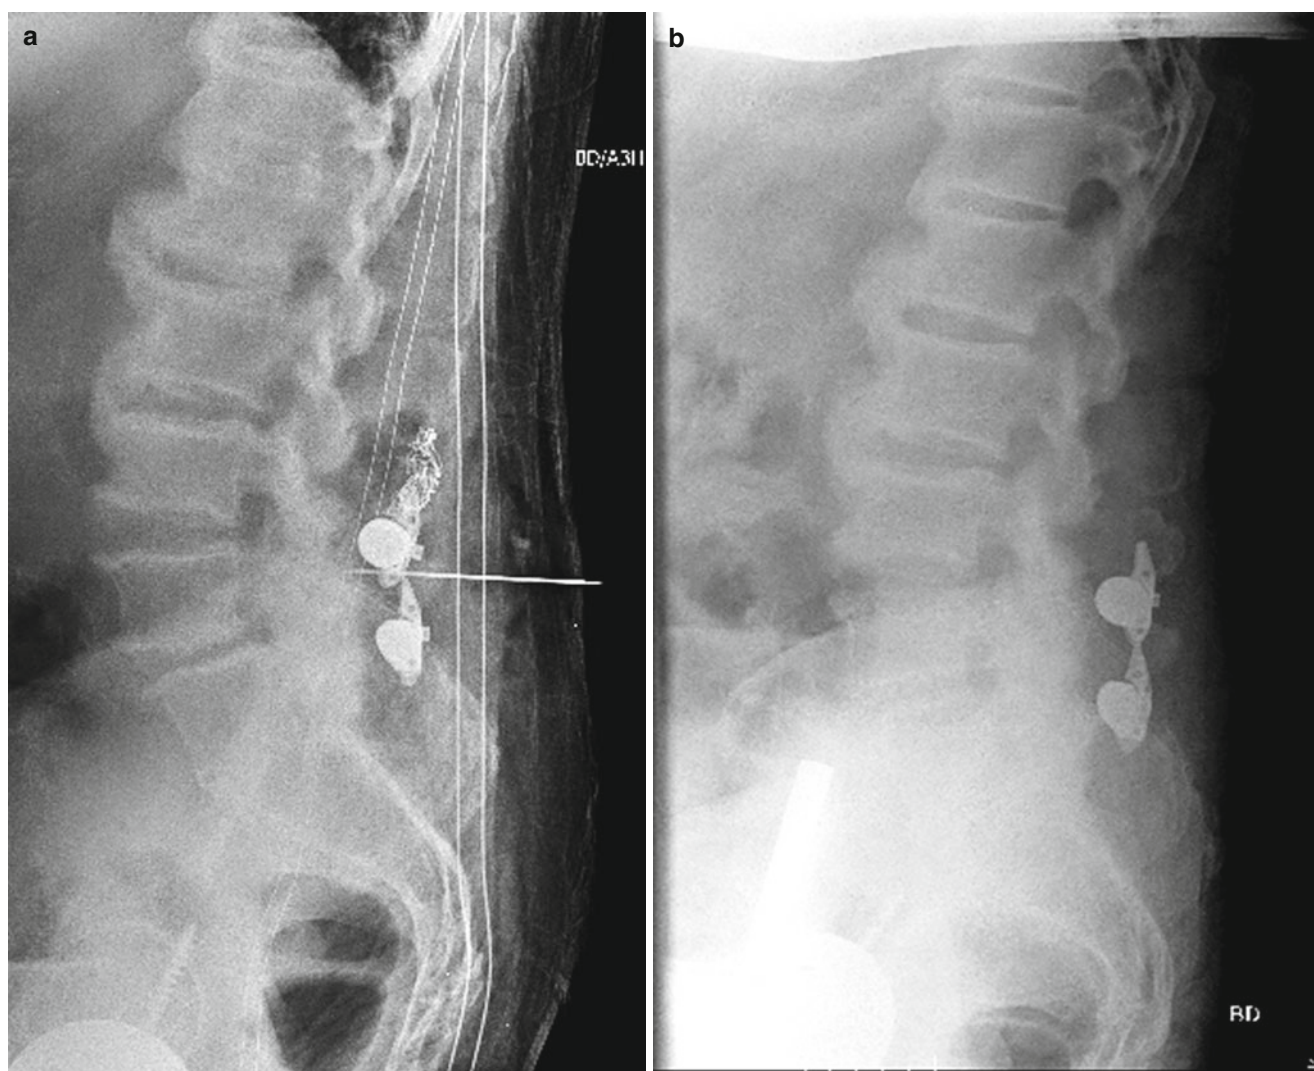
Same patient from Fig. 26.1. Patient underwent a two-level X-STOP procedure seen on (a) intraoperative lateral radiograph. At two years, the patient continued to have very good relief of his symptoms with (b) radiographs showing maintained position of the X-STOP device
